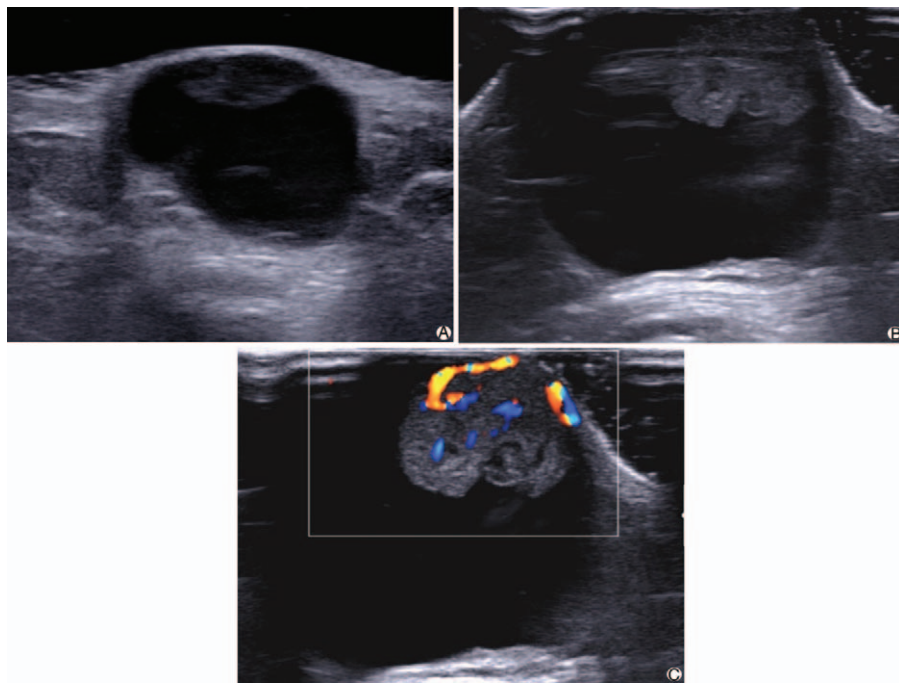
Ultrasonographic image of poroid hidradenoma of the breast. (A) Ultrasound image obtained at the initial visit shows a 2.2 cm well-circumscribed oval complex cystic and solid mass abutting the dermis and the subcutaneous layer of the right breast. (B and C) Ultrasound revealed a 3 cm complex cystic and solid mass with a hypervascular microlobulated solid nodule in the nondependent portion of the lesion after 2 years.
